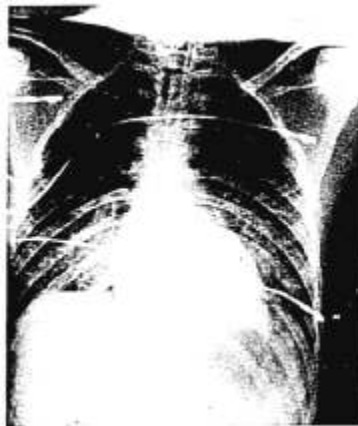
Chest roentgenogram one hour postoperatively, showing an interstitial infiltrate consistent with pulmonary edema.
